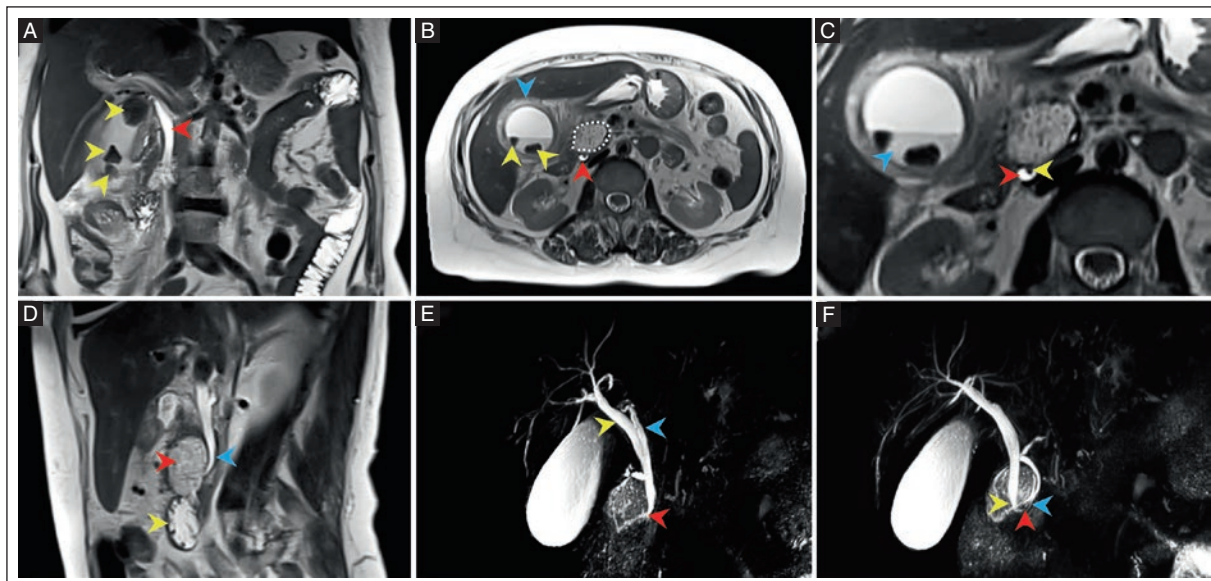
3.0T MRI of a 71-year-old woman with abdominal pain and jaundice diagnosed with Lemmel syndrome. A: coronal T2-weighted HASTE view shows a distended gallbladder with hypointense areas suggestive of gallstones (yellow arrowheads) and proximal common bile duct dilatation (red arrowhead). B: axial T2-weighted HASTE view shows a distended gallbladder with wall thickening (blue arrowhead), a fluid level and intraluminal hypointense images consistent with gallstones (yellow arrowheads). A saccular formation (dashed line) is seen exerting a mass effect on the distal common bile duct (red arrowhead). C: axial T2-weighted HASTE view shows a fluid level with biliary sludge (blue arrowhead), a distal common bile duct segment (red arrowhead), and an intraductal microstone (yellow arrowhead). D: sagittal T2-weighted HASTE view shows a saccular image (red arrowhead) arising from the second segment of the duodenum (yellow arrowhead) compressing the distal common bile duct (blue arrowhead). E: 3D MIP reconstruction shows a saccular formation compressing both the common bile duct and the pancreatic duct (red arrowhead) and dilatation of the common hepatic duct (yellow arrowhead) and the cystic duct (blue arrowhead). F: a 3D MIP reconstruction shows compression of the common bile duct (yellow arrowhead) and the pancreatic duct (blue arrowhead). The Vater papilla is within the diverticulum (red arrowhead). The diagnosis was Lemmel syndrome, type I PAD, according to the Boix and Li-Tanaka classifications.
